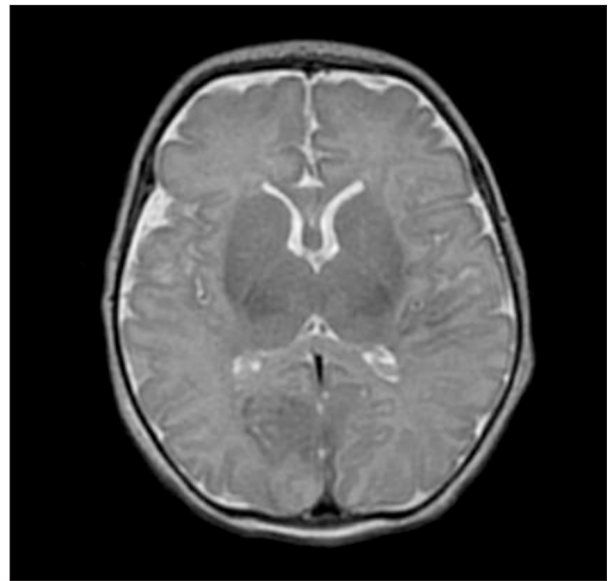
MRI brain T2-weighted imaging showing underlying normal brain structure.
